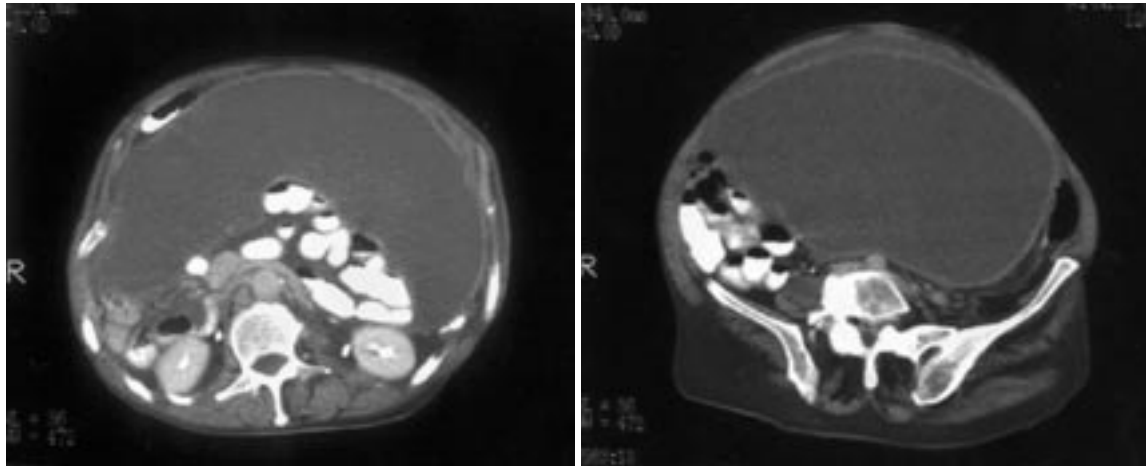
Abdominopelvic computed tomography scans showing a cystic-colloid lesion. It is thin-walled and the hole is left-sided due to mass effect.
